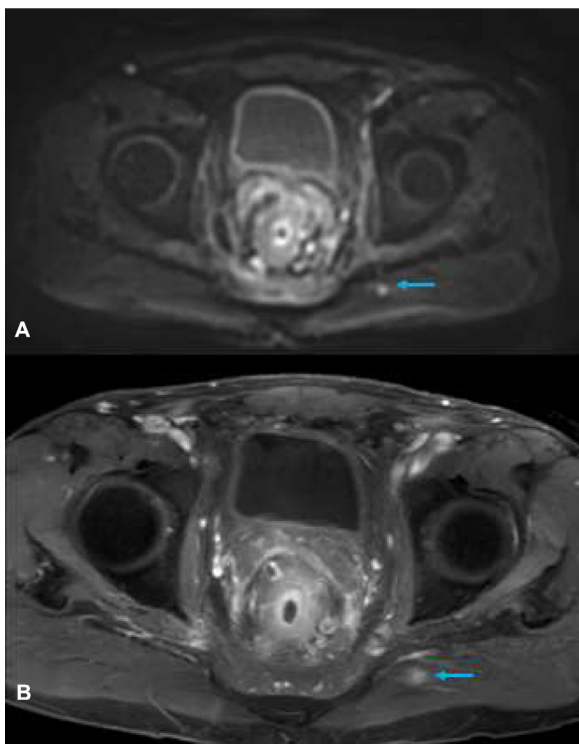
DWI sequence (A) and axial T1 FAT SAT postcontrast sequence (B) showing the left buttock metastatic nodule (blue arrow).
